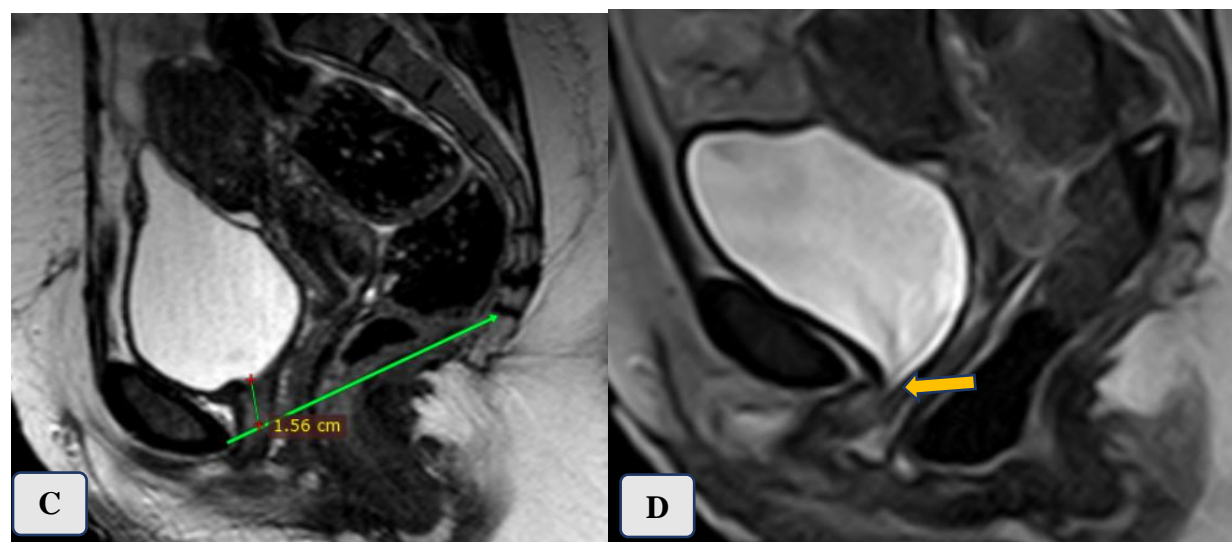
52 years old, presented with SUI. UD shows VLPP=75cmH₂O, MUCP=50cmH₂O. (A) Axial T2WI shows loss of H shape configuration of the vaginal with bilateral symmetrical thinning of the PRM. (B) Sagittal T2WI shows increased vesicourethral angle measuring about 143°. (C) Sagittal T2WI shows decreased length of the suprapubic urethra. (D) Dynamic MRI of the pelvis with maximum straining shows funneling of the UB neck.
